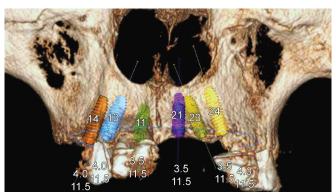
Three-dimensional reconstruction view (CBCT) of anterior maxilla showing pre-osteotomy planning of different implant dimensions, implant angulations and interimplant distances that could provide optimal treatment outcomes with minimum complications. Additionally, visualization of the bony morphology, nerve patterns, joint structures, position, and extent of maxillary sinuses can be done more comprehensively than routine two-dimensional radiography
